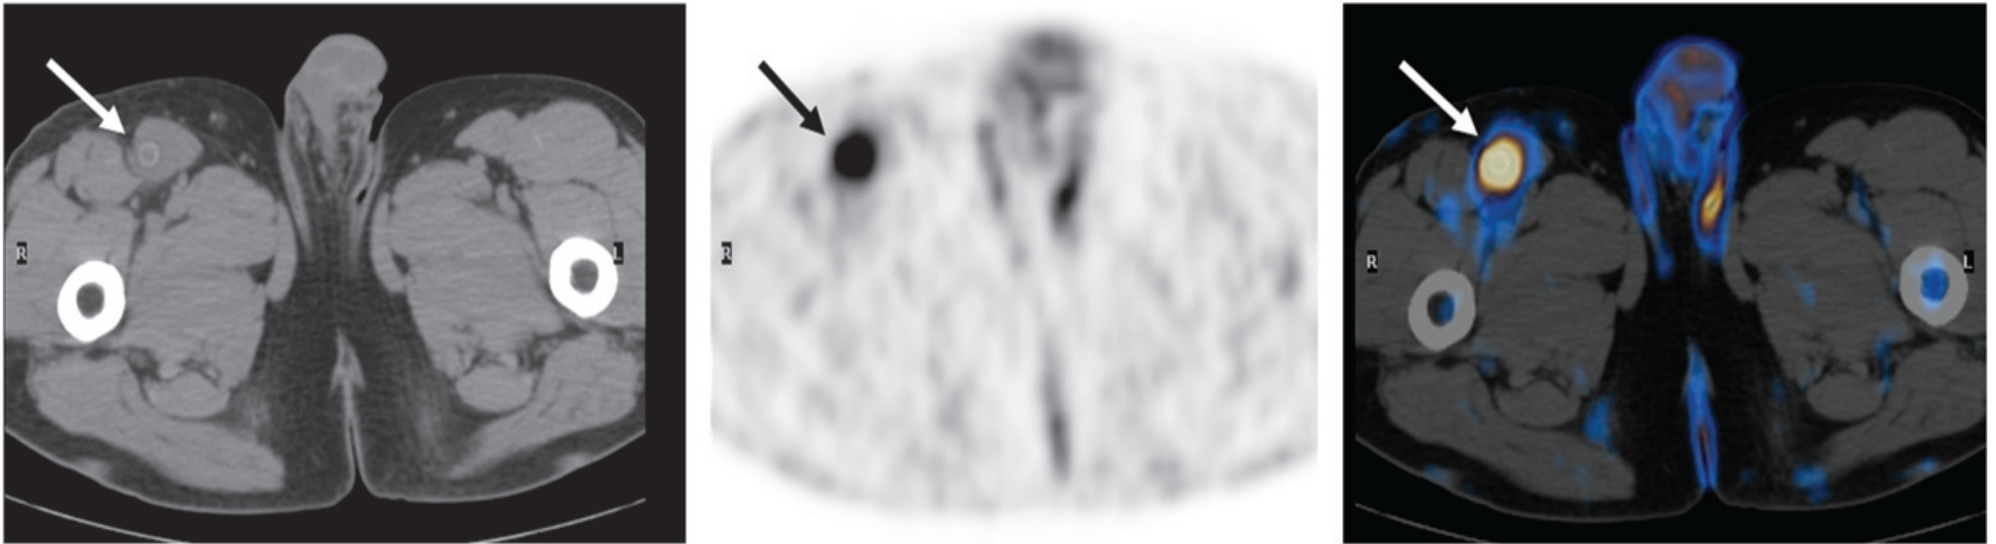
A 54-y-old man who had received right femoropopliteal bypass graft 3 mo previously. Infection was clinically suspected because of fever and local pain in right groin. ^{18}F -FDG PET (center) demonstrates focus of increased tracer uptake in right groin (arrow), localized by PET/CT (right) to right femoropopliteal vascular graft as seen on CT (left, arrow). Graft was considered to be involved by infectious process. Diagnosis was confirmed at surgery, and infected graft was removed.
